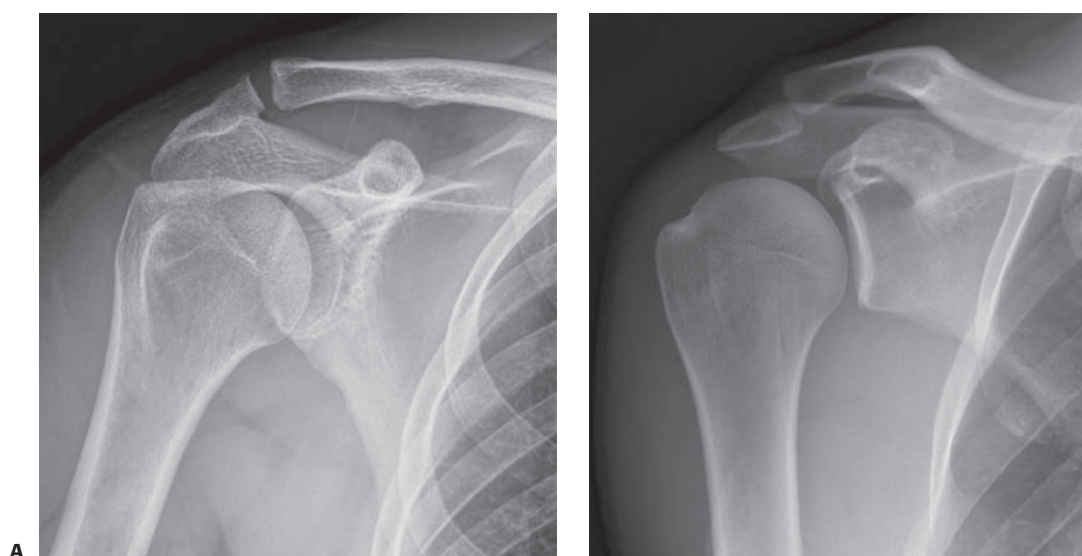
A: Anterior–posterior radiographic view of the shoulder. B: Grashey true view.
